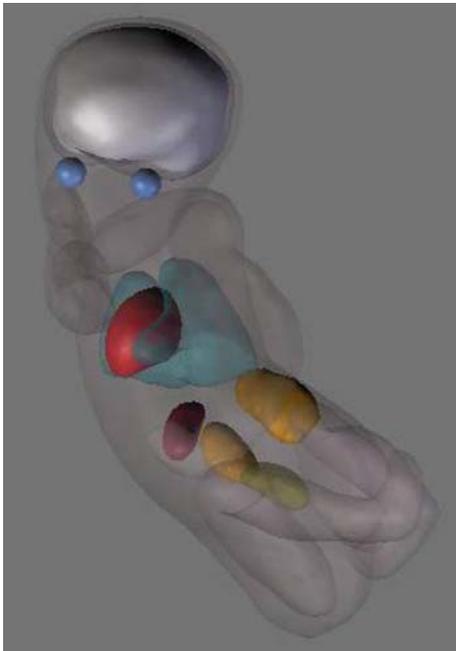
Fetus envelope and internal organs extracted from an MRI data set: the transparent fetus envelope contains the brain (*gray*), the eyes (*blue*), the heart (*red*), the lungs (*cyan*), the stomach (*purple*), the kidneys (*orange*), and the urinary bladder (*yellow*)
